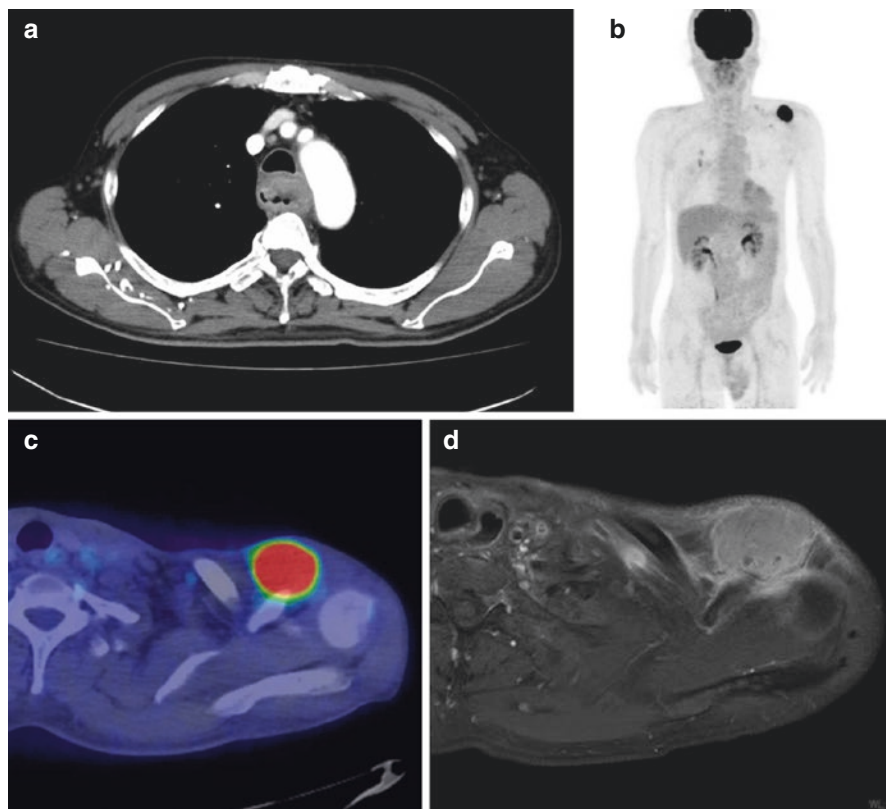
A 50s' male with surgically treated esophageal cancer. (a) A preoperative contrast-enhanced CT depicts a tumor in the upper third of the thoracic esophagus. (b) The postoperative follow-up FDG maximum intensity projection image detects abnormal strong uptake around the left shoulder. (c) A FDG/PET fusion image depicts strong uptake in the muscle around the left shoulder joint. (d) A MRI gadolinium-enhanced T1-weighted image shows a heterogeneously enhanced mass in the muscle around the left shoulder joint. The subsequent biopsy confirmed the diagnosis of intramuscular metastasis from esophageal carcinoma
